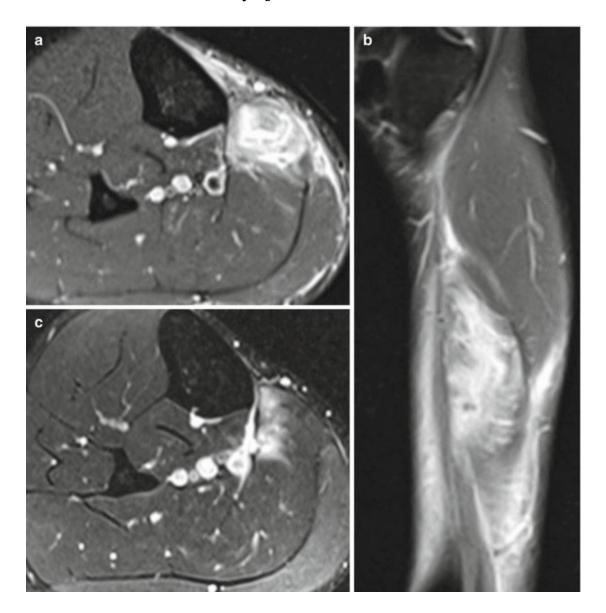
Axial (a) and sagittal (b) fat-suppressed T2-weighted MRI of the right mid-calf show severe muscle contusion of the soleus associated with rupture of the superficial aponeurosis. Follow-up axial fat-suppressed T2-weighted MRI (c) shows partial healing of the muscle lesion with important decrease of the hyperintense lesion
